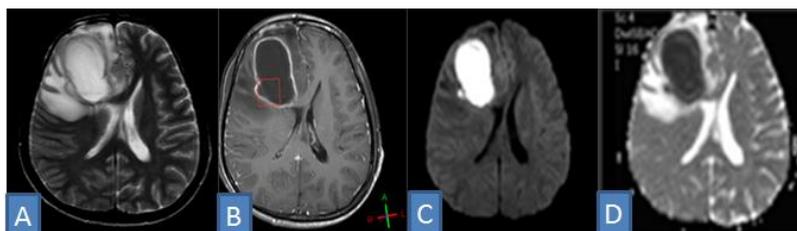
A case of right frontal lobe abscess appearing hyperintense on T2W images with hypointense rim and extensive perilesional edema (A), showing peripheral rim enhancement in contrast (B) and showing restriction on DWI (C) , with low ADC values (D).
